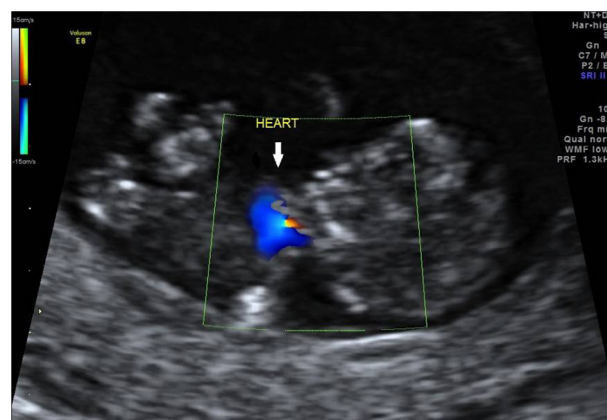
Fetal heart exposed outside the thoracic cavity of Twin B at 9 weeks' gestation. The anatomical structure appeared normal. Color Doppler scan confirmed the cardiac structure of the bulging mass.
